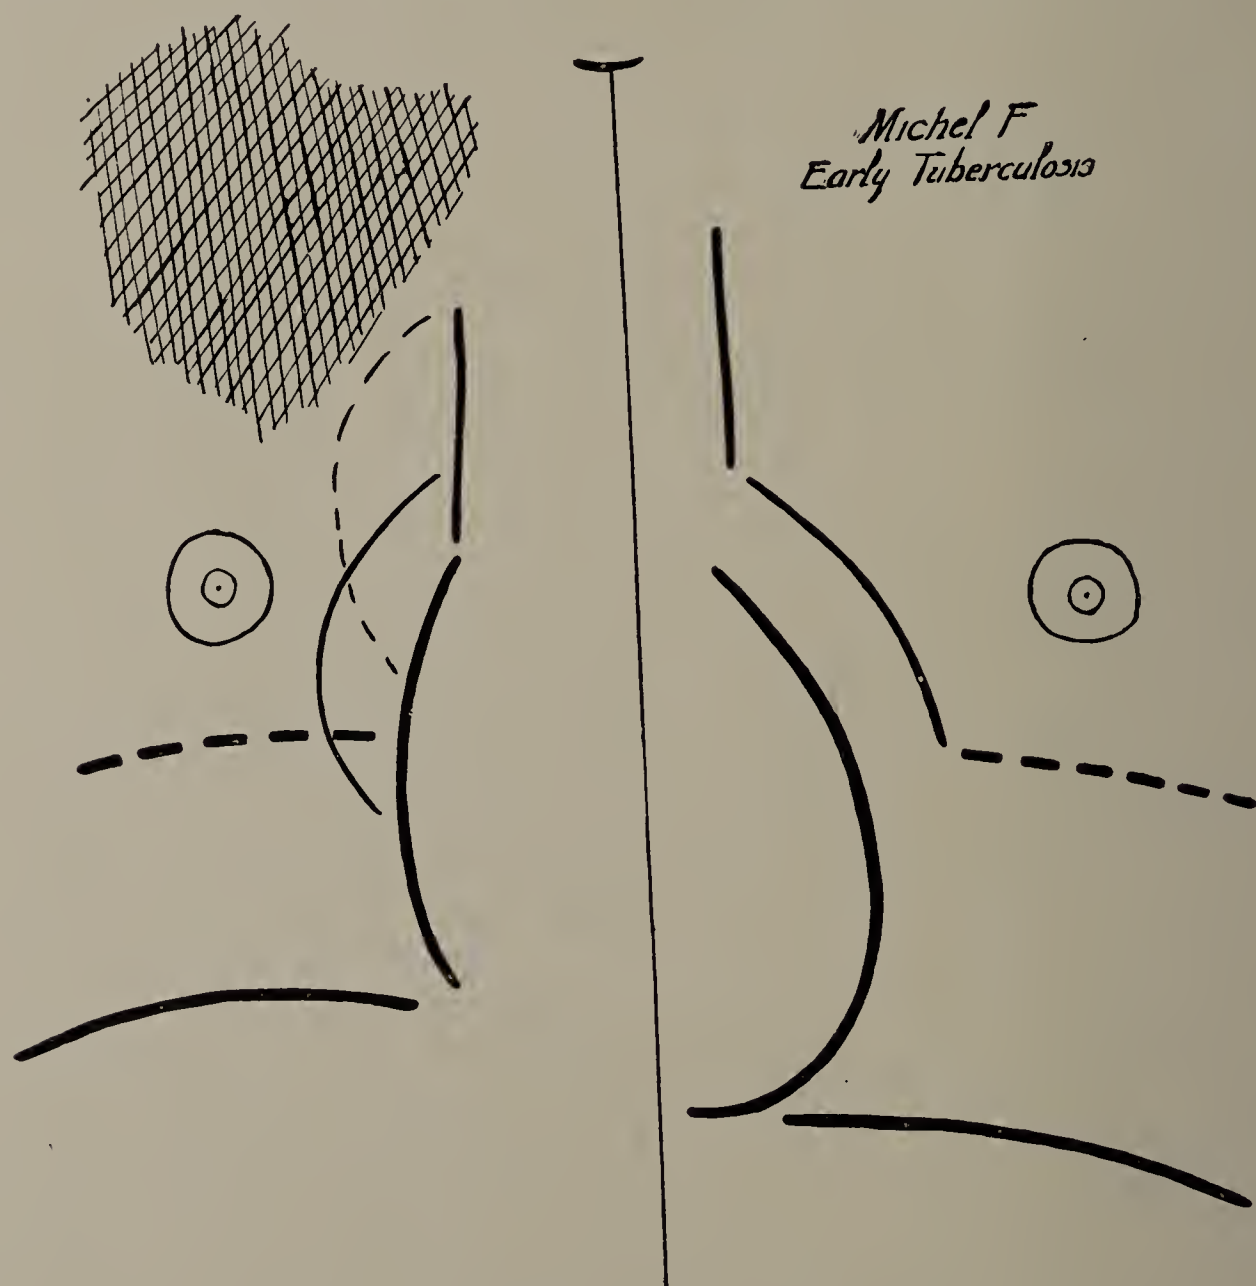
Michel F., December 17, 1898. Diagnosis: acute articular rheumatism. X-ray examination with screen shows that the apex on the right side is darkened. Broken and nearly horizontal lines on either side show position of diaphragm in expiration; the full lines below, in forced inspiration. It will be noticed that the excursion of the diaphragm on the right side is shorter than on the left. The heart during forced inspiration moves more to the right than normal, because the right lung expands less than the left. (One-third life size.)
